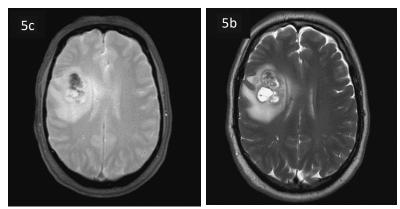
5: 5c: axial T2 GRE; 5b: axial T2 FLAIR. Adapted from: Case of A.Prof Frank Gaillard, Radiopaedia.org, rID: 5322
